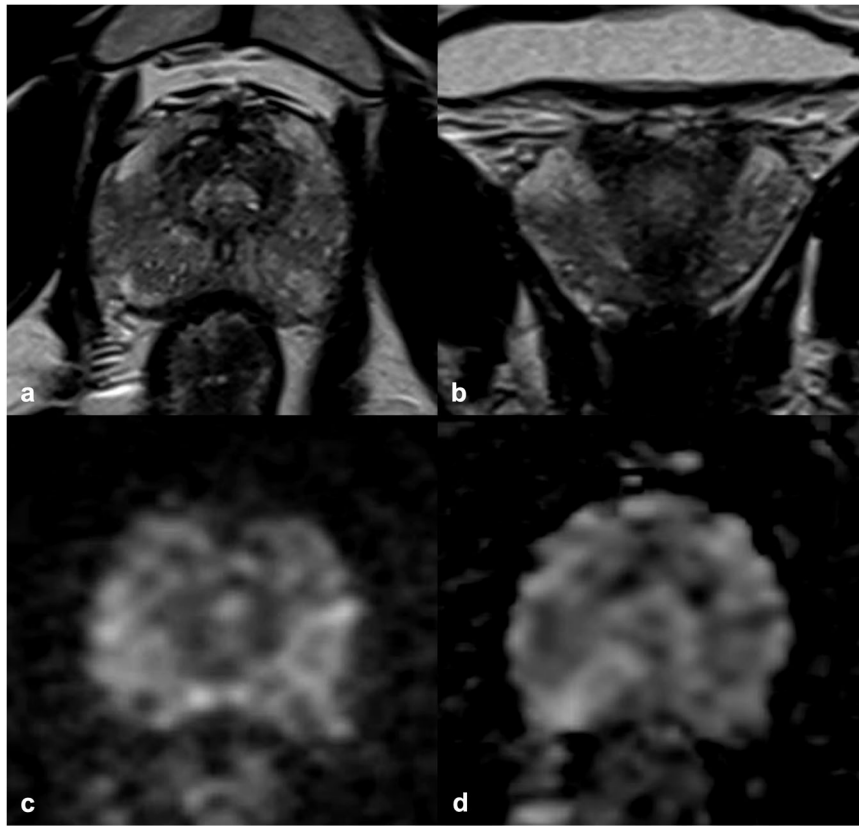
50-year-old man undergoing screening MRI with a PSA value of 0.7 ng/mL and no clinical suspicion of prostate cancer. a, b axial and coronal T2WI show diffuse heterogeneous hypointensity of the peripheral zone. c DWI (b-value = 2000) demonstrates slight homogeneous hyperintensity of the peripheral zone, with corresponding homogeneous diffused hypointensity on the ADC map d. No suspicious lesions were identified, and an overall PI-RADS 2 score was assigned; the PSA-Density resulted 0.02 ng/mL². *PSA prostate-specific antigen, T2WI, T2-weighted imaging, DWI diffusion-weighted imaging, ADC apparent diffusion coefficient, PI-RADS Prostate Imaging Reporting and Data System.*
